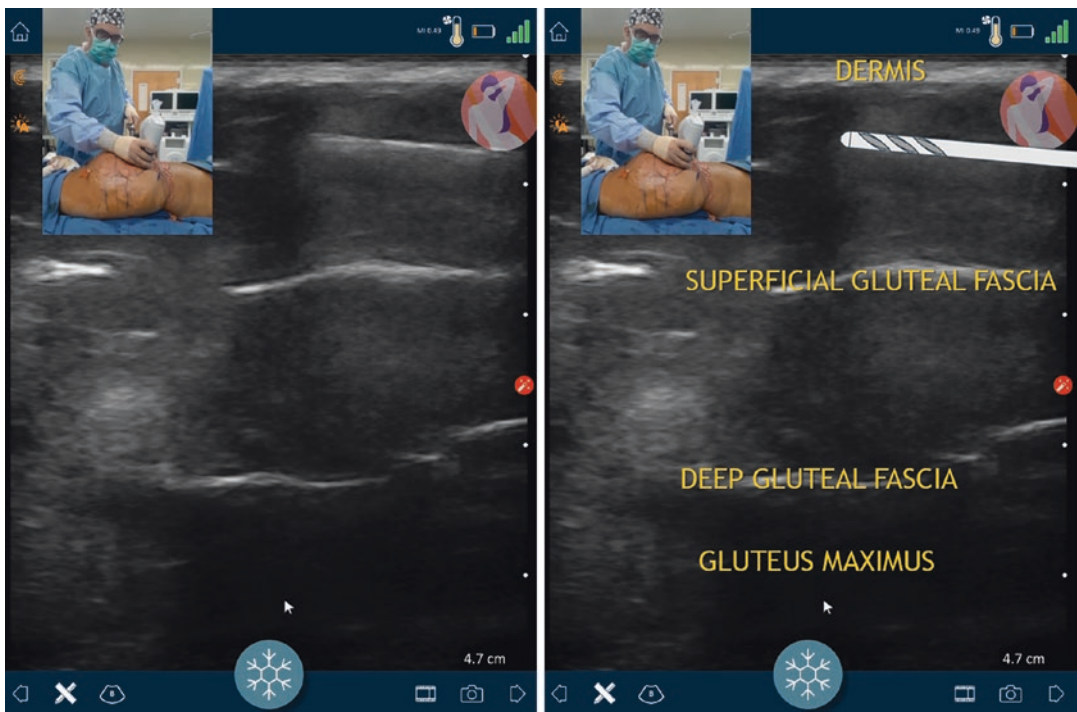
Supragluteal contour, preinjection. The “candy cane” cannula is above the superficial gluteal fascia within the superficial subcutaneous space. Ultrasound guidance allows for precise targeting of thin subcutaneous spaces
